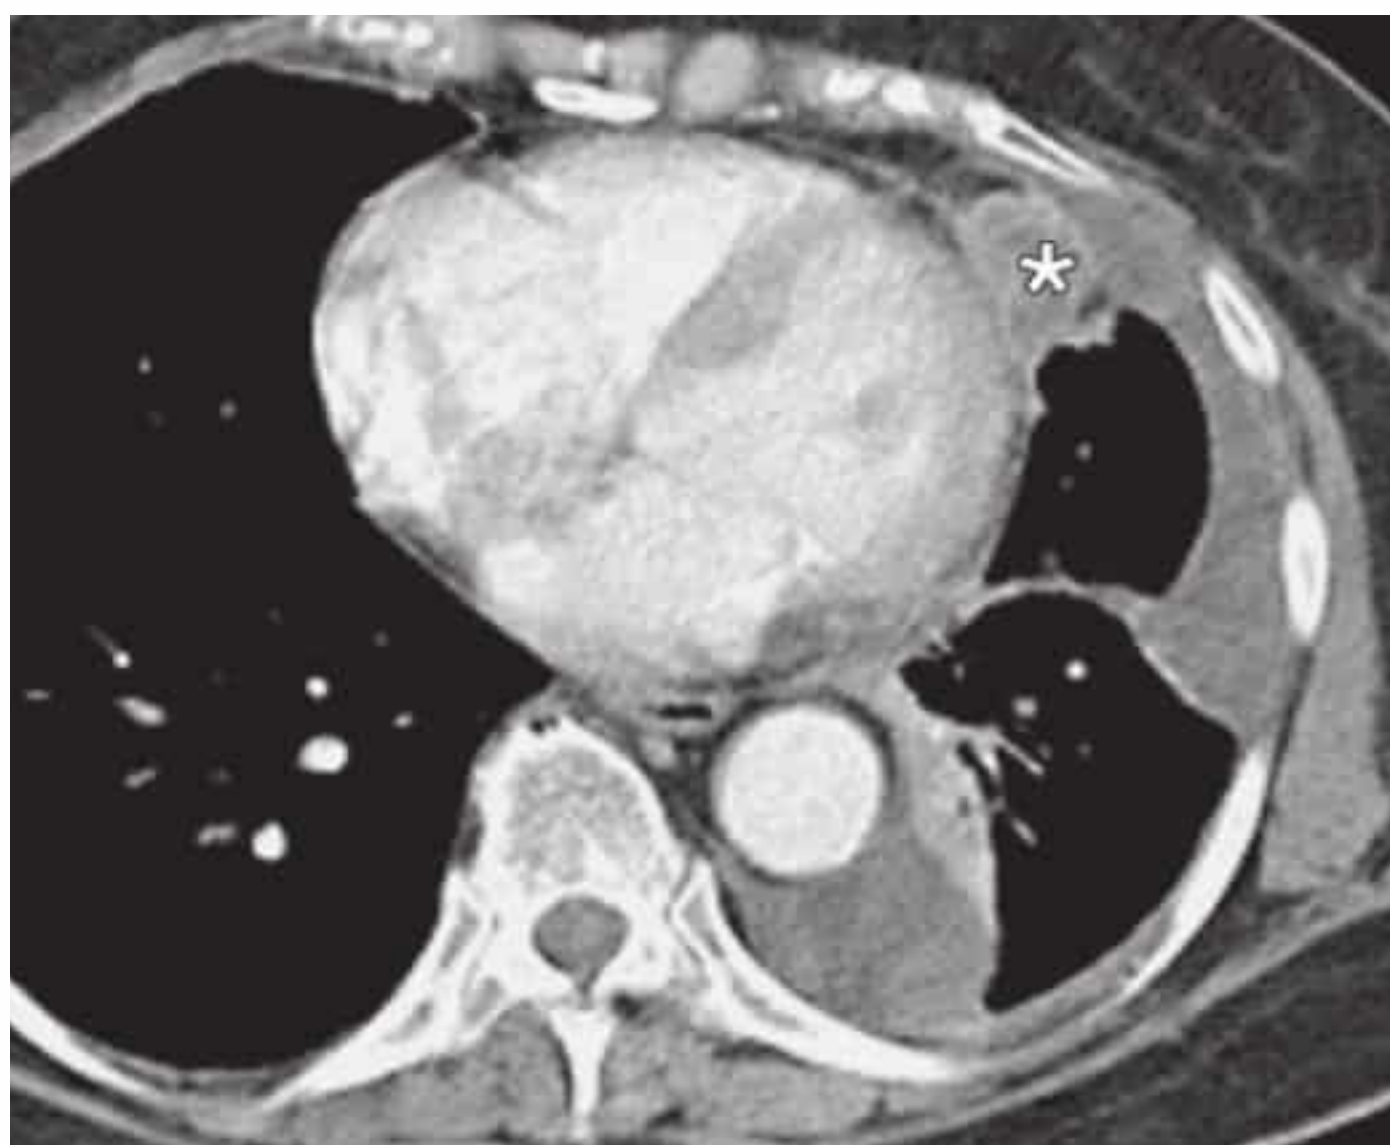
Pericardial metastasis from breast carcinoma (asterisk). Contrast-enhanced CT.
